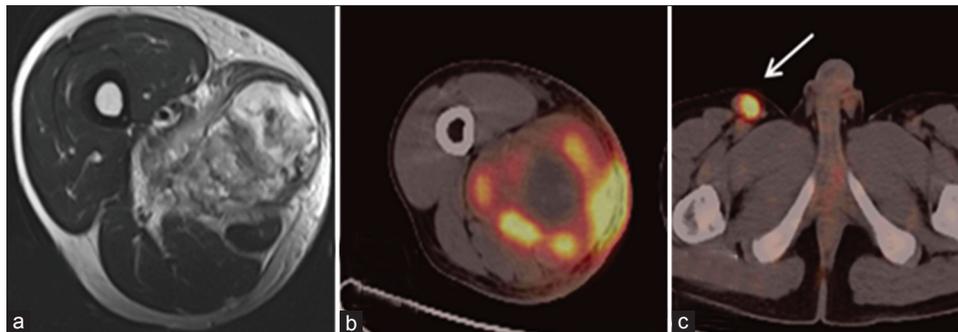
False positive lymph node metastasis on positron emission tomography-computed tomography (PET-CT): Magnetic resonance imaging of 21-year-old male with synovial sarcoma involving of right thigh shows characteristic triple signal intensity on T2W image (a). On PET-CT tumor show high ¹⁸F-FDG uptake (b). High uptake was also seen in inguinal lymph node (arrow) on PET-CT (c)
